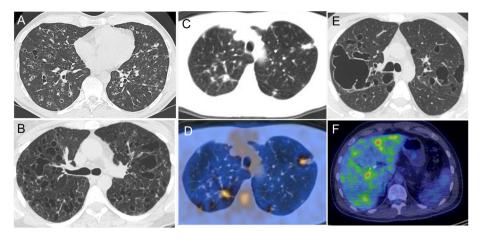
(A) Representative high-resolution chest CT image from a patient with biopsy-proven pulmonary Langerhans cell histiocytosis (PLCH) demonstrating a combination of small nodules, cavitary nodules and lung cysts. (B) Representative chest CT image from a patient with advanced biopsy-proven PLCH demonstrating cystic lung lesions of varying sizes and appearance. Nodular change is not apparent. (C and D) Corresponding chest CT and positron emission tomography (PET) images from a patient with biopsy-proven PLCH showing nodular lesions on the chest CT which are hypermetabolic on the PET. (E) Representative chest CT image from a patient with biopsy-proven systemic Langerhans cell histiocytosis with pulmonary, liver and bone involvement. The chest CT image demonstrates cystic changes with formation of a bullous like abnormality in the right upper lobe. (F) Representative PET image showing hypermetabolic liver lesions from the same patient whose chest CT is shown in panel E.
